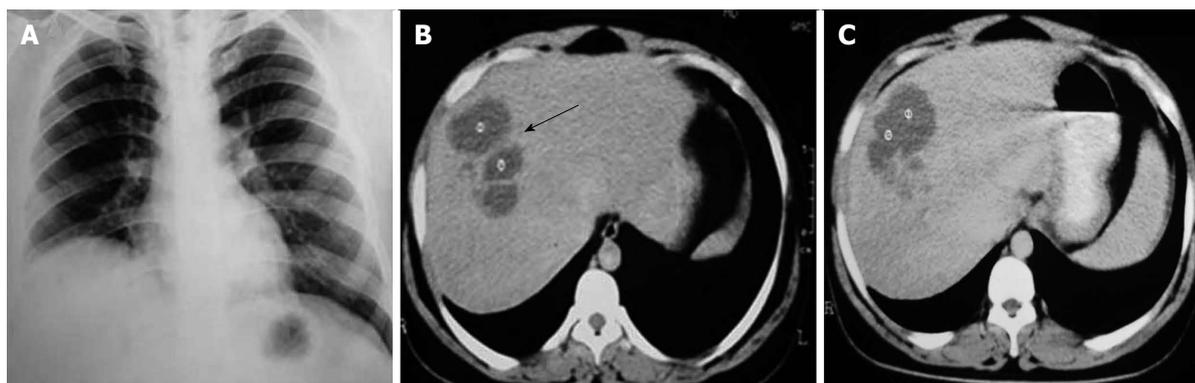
Computed tomography. A: Chest radiograph shows elevation of right hemi-diaphragm; B: Contrast enhanced computed tomography of upper abdomen shows one loculated hypodense lesion (8.5 cm × 7.4 cm) with irregular inner margin noted in the right lobe of liver (black arrow); C: Multiple small hypodense lesions with confluences also seen in posterior part of right lobe.
